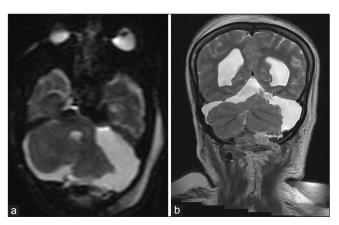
Following magnetic resonance images showing the reduction in the size of cyst and also reduction in the mass effect over cerebellum and brain stem structures
